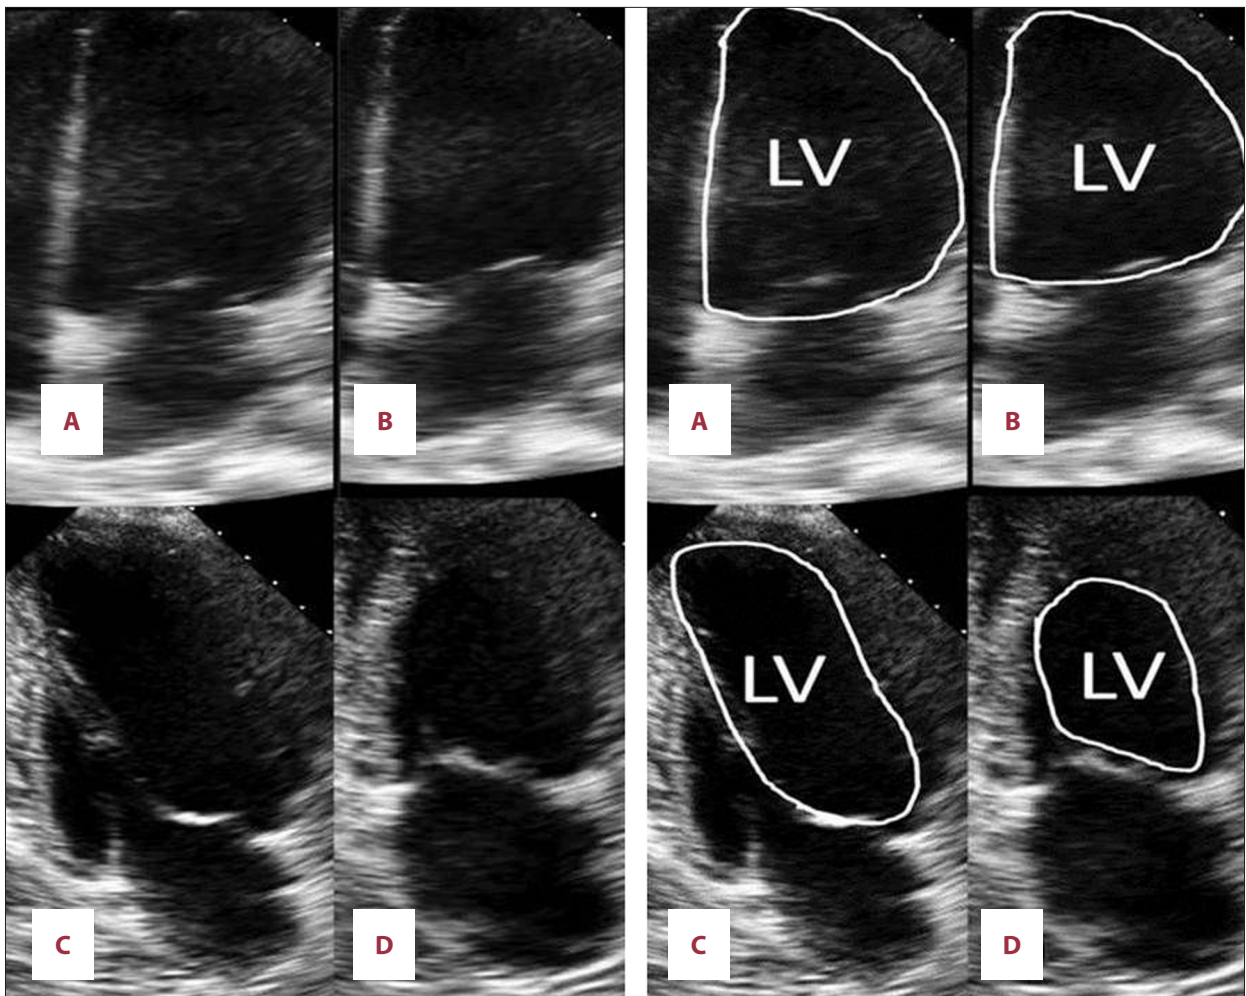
Serial echocardiographic findings: (A, B) diastolic and systolic images at presentation; (C, D) diastolic and systolic images at 20 week follow up. LV – left ventricle.
